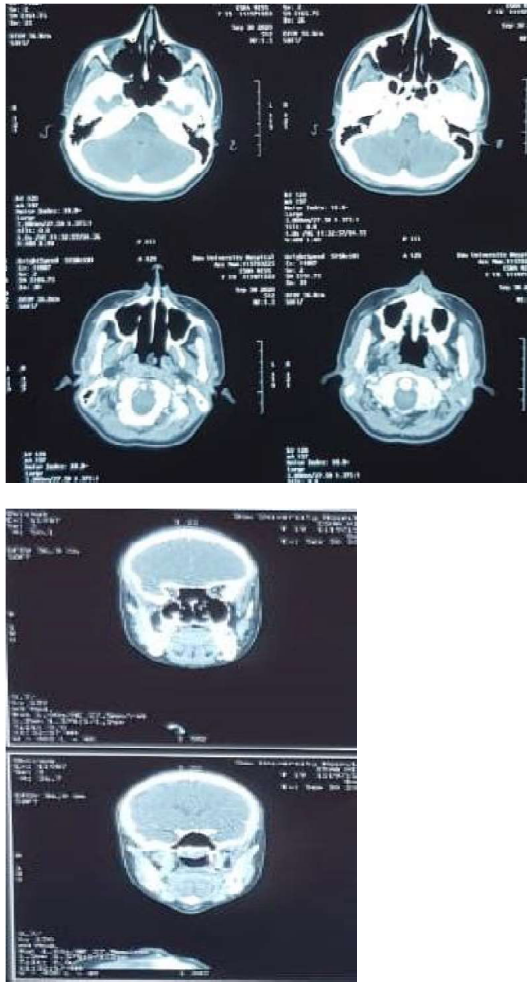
CT Scan neck with contrast.
